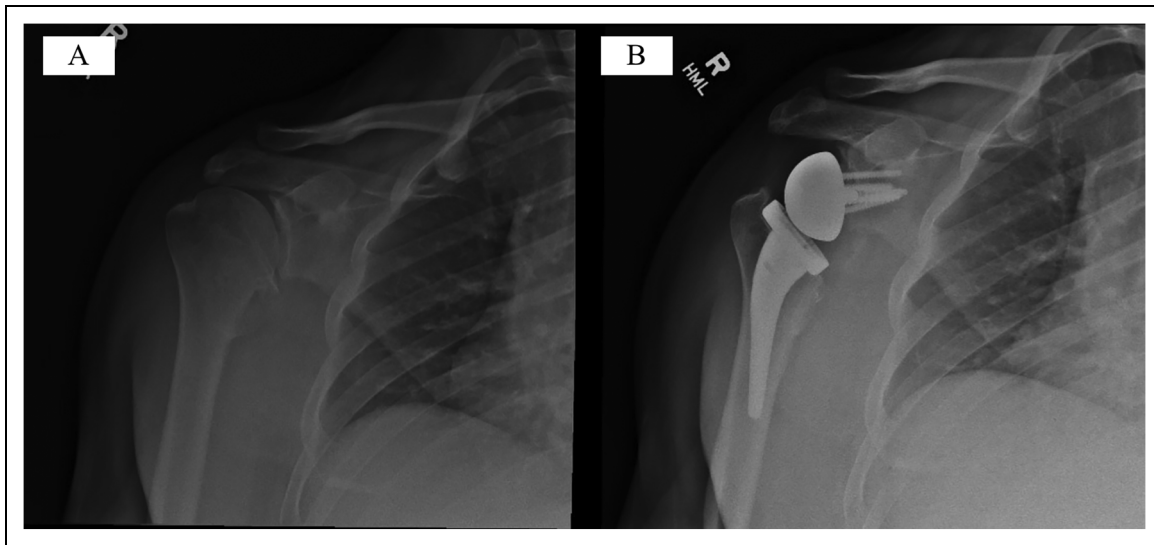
(A) Preoperative and (B) postoperative radiographs of a 42-year-old man treated with RTSA using a bony augment baseplate.
